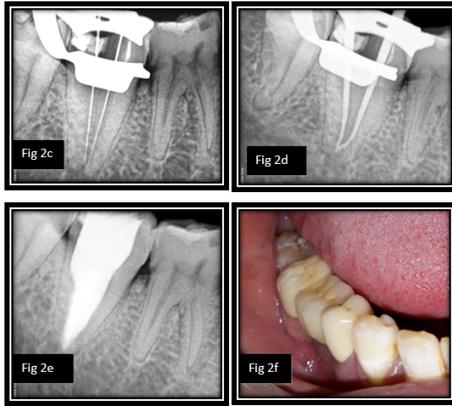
preoperative radiograph, Fig 2b-access cavity preparation showing melton's classification II, Fig 2c-working length determination, Fig 2d-Master cone selection, Fig 2e- obturation, Fig 2f- Crown placement
